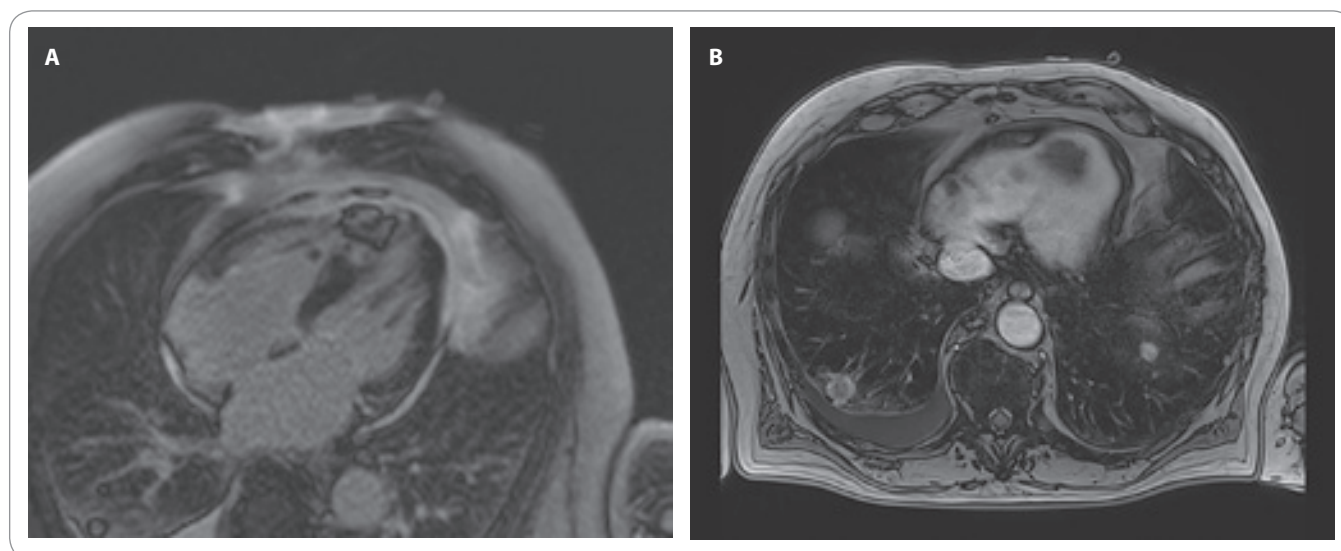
Selected cardiac MRI images demonstrating the apically located metastasis. (A) Late gadolinium enhancement (LGE) scan showing involvement of the apex; (B) T1-weighted, axial (transverse) 3D GRE Dixon image (also showing lung metastases).
